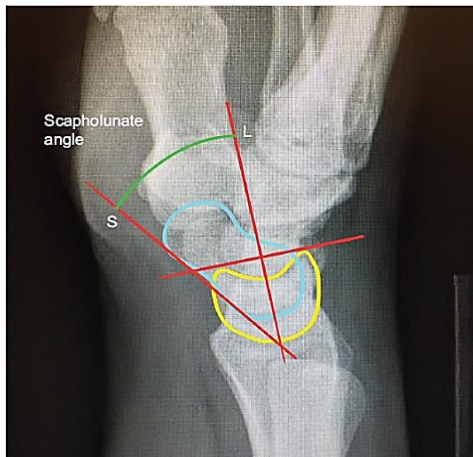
Increased scapholunate (SL) angle in the lateral wrist x-ray. The angle is created between the long axis of the scaphoid and the mid axis of the lunate. SL angle > 60 is suggestive of dorsal intercalated segment instability (DISI). [Adapted with permission from Konopka and Chim Copyright 2018. Orthopedic Research and Reviews (12). (Adapted with permission from Dove Medical Press)]
